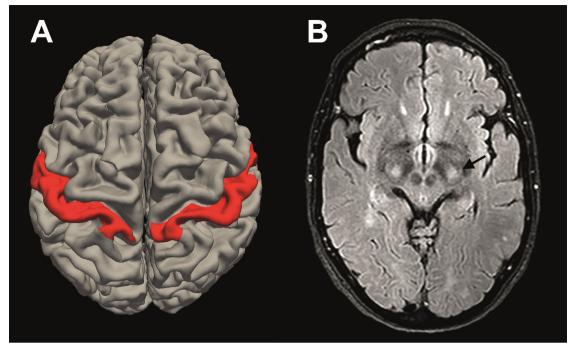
Neuroimaging changes in amyotrophic lateral sclerosis. A: motor cortex (red) atrophy. B: axial T2-FLAIR (fluid attenuated inversion recovery sequence) magnetic resonance image at level of midbrain, showing hyperintensity in cerebral peduncles corresponding to corticospinal tracts (black arrow)
